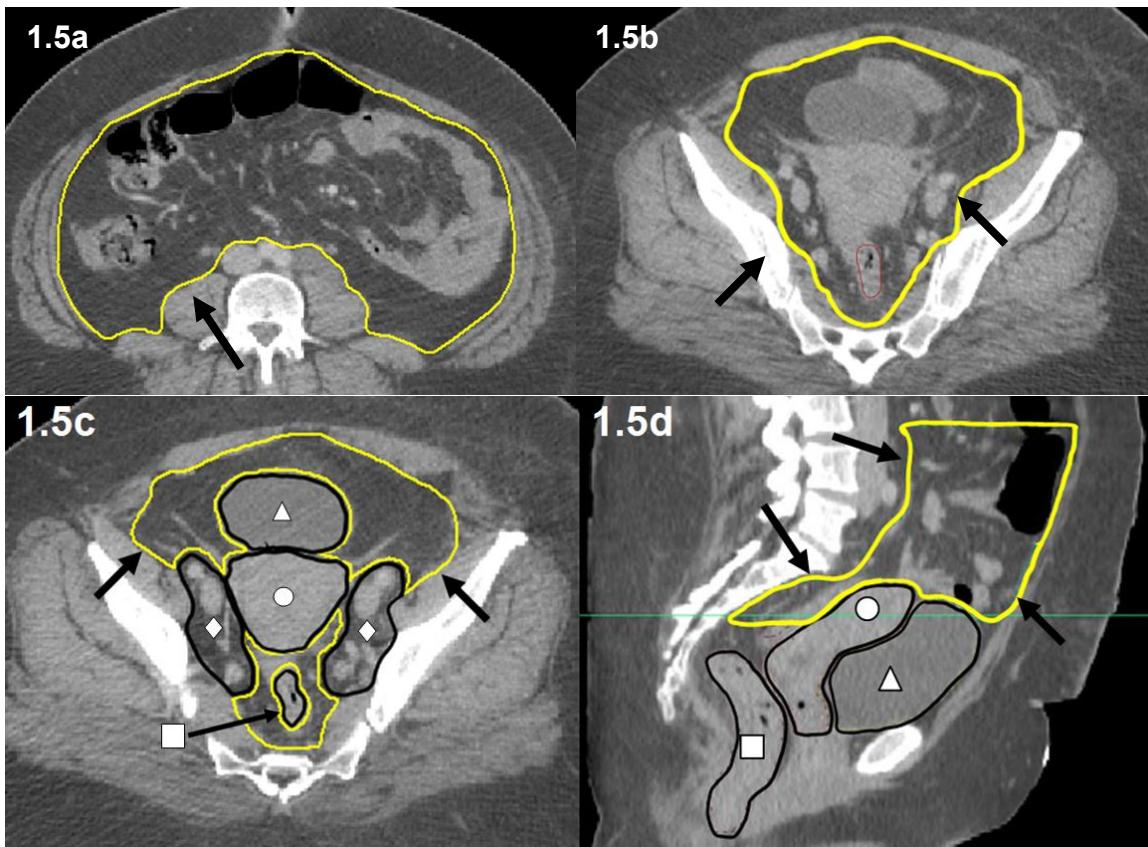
Axial (a,b and c) and sagittal (d) CT with bowel bag outlined (yellow) and bladder (triangle), rectum (square), uterus/CTV1 (circle) and CTV2 (diamond) edited out of the initial volume
